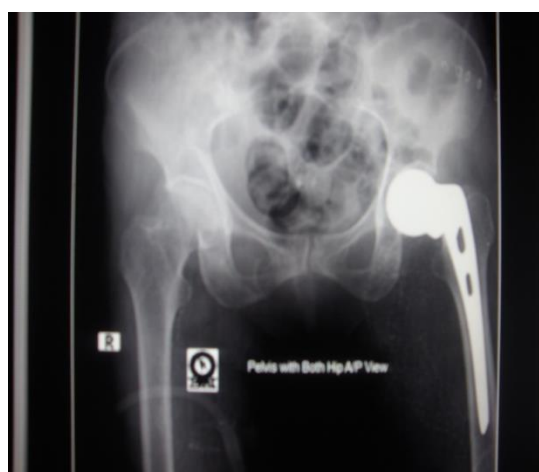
X-RAY of a post- operative patient with hemiarthroplasty
